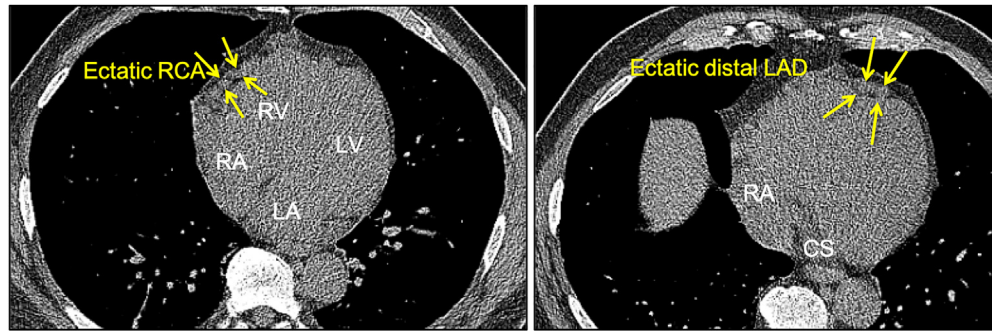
Noncontrast chest CT ordered for lung cancer screening showed multiple serpiginous vascular structures along the right-ventricular free-wall corresponding to an ectatic right coronary artery (left panel, yellow arrows) and along the apex of the heart corresponding to ectatic distal left coronary artery (right panel, yellow arrows) as well as area of fistulization. RCA, right coronary artery; LAD left coronary artery; RA, right atrium, LA, left atrium; RV, right ventricle; LV, left ventricle; CS, coronary sinus.
